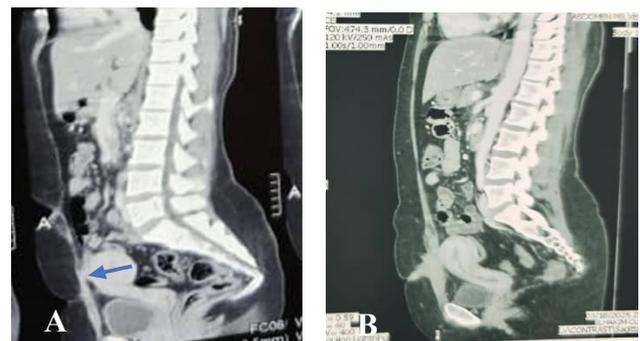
On computed tomography scan, the sagittal plane shows the anterior wall of the uterus adherent to the subcutaneous tissue of the anterior abdominal wall near the scar, as in photo A, extends through the abdominal wall up to the scar site as seen in photo B
